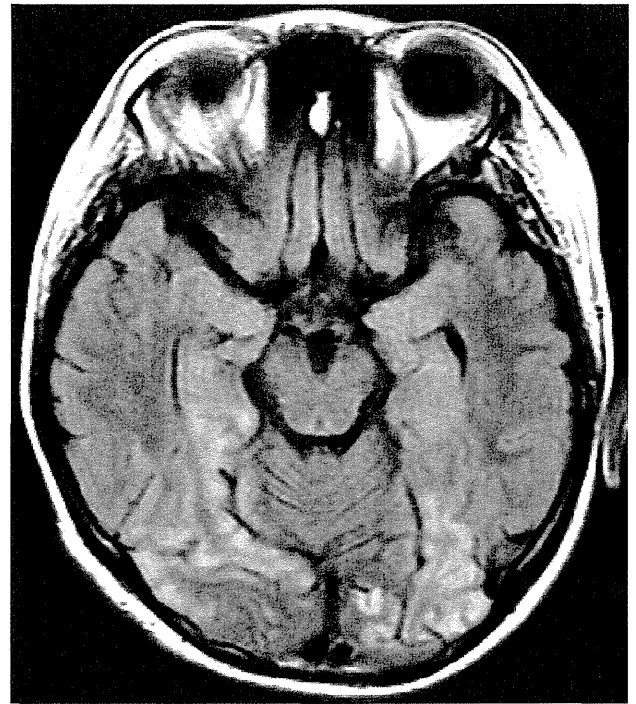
Brain magnetic resonance imaging of the patient (fluid-attenuated inversion recovery imaging). Bilateral occipital lesions with high signal intensity are noted, whose distribution is not conforming to that of vascular territories.
